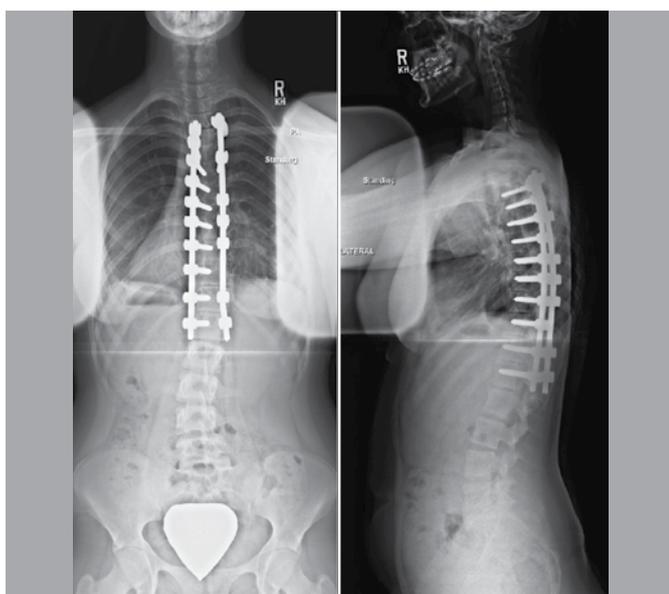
Two-year postoperative radiographs of patient treated with PSF with higher implant density, 1.7.
